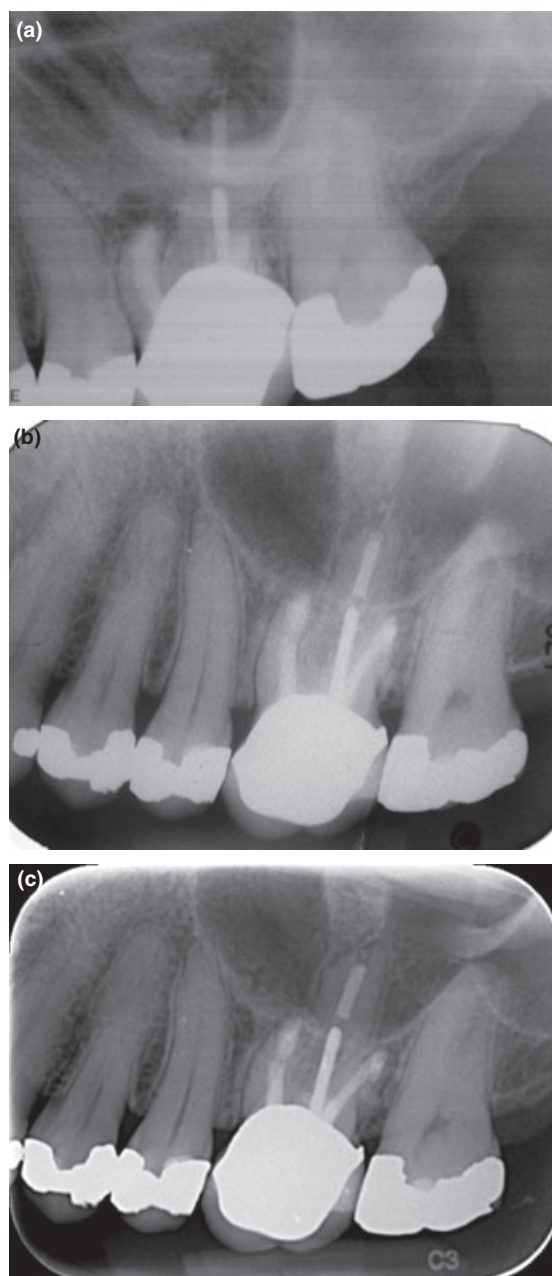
(a) Postoperative radiograph taken after endodontic surgery. (b) 7-month recall radiograph. (c) 2-year recall radiograph.
